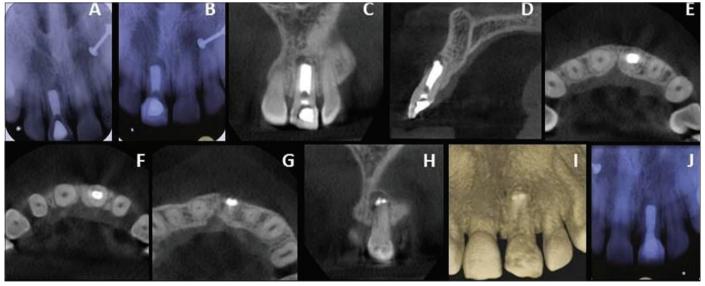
(a) IOPA radiograph at 1 month. (b) IOPA radiograph at 3 months showing healing of the periapical lesion. (c) CBCT image in coronal plane at 3 months. (d) CBCT image in sagittal plane at 3 months. (e) CBCT image in axial plane at coronal third of root at 3 months. (f) CBCT image in axial plane at middle third of root at 3 months. (g) CBCT image in axial plane at apical third of root at 3 months showing increased bone density in the lesional site around MTA filling. (h) CBCT image in coronal plane at 3 months showing increased radiopacity in the lesional site around MTA filling. (i) 3D CBCT image at 3 months showing unchanged morphology of the MTA filling in lesional space. (j) IOPA radiograph at the end of 6 months showing apical closure of the root and healed periapical area.
